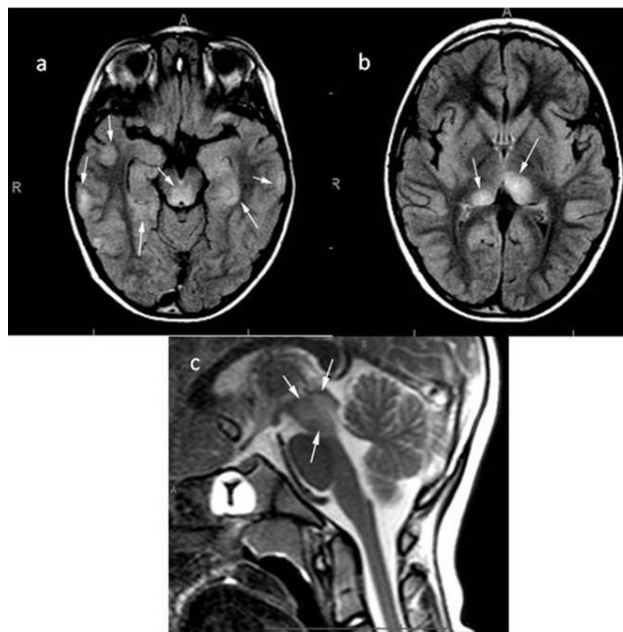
Initial cranial MRI transverse FLAIR (Fluid attenuated IR) images (a,b) show brain stem, multiple cerebral cortex and thalamic lesions. Sagittal T2 weighted image (c) shows prominent mesencephalon involvement (arrows).
